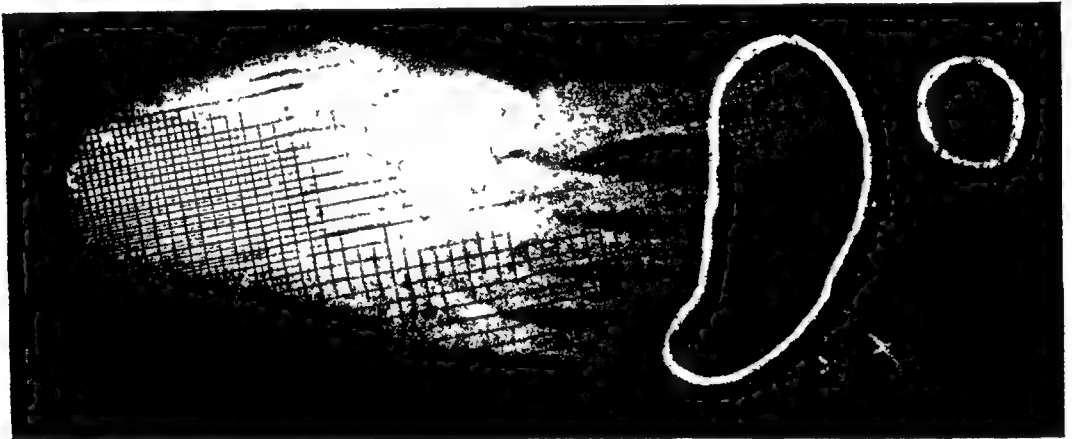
ORTHODYNAMIC RADIOGRAPH (X-RAY PAPER). Lesser toes make little purchase; excess imprint all metatarsophalangeal joints and distal great toe area.
